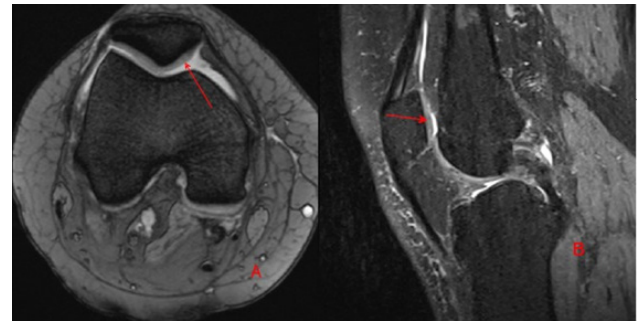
MRI after PRP injection, (A) Axial T2WI revealed improvement as regards the articular cartilage volume and (B) Sagittal STIR images revealed improvement as regards the articular cartilage and subchondral bone edema.
